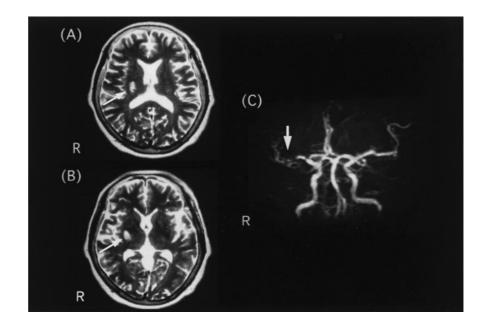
A–C The case of pure lacunar infarction. A, B Lacunar infarction at left corona radiata (*arrow*) was observed on T2-weighted image. It showed many accompanying silent subcortical lesions such as PVH and spotty hyperintensity lesions in basal ganglia and deep white matter. C Magnetic resonance angiography was normal
